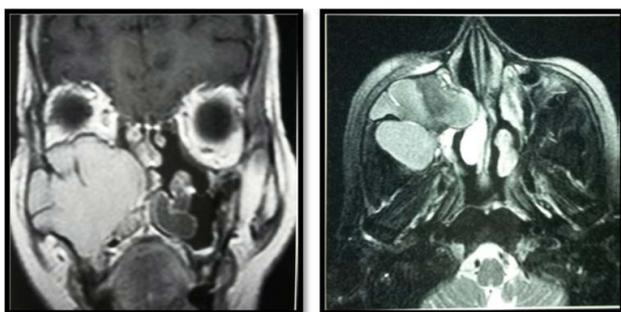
Axial and coronal MRI imaging showing a maxillary mucocoele with extension toward the orbite and the infra temporal fossa.
